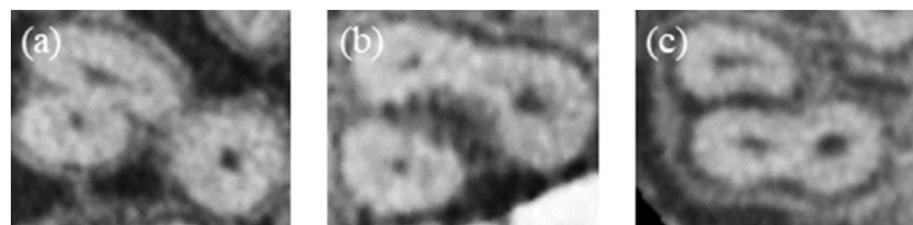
Representative CBCT scans of maxillary first molars exhibiting root fusion classified with the Zhang classification.²³ (a) Type 1; the MB root is fused with DB root. (b) Type 2; the MB root is fused with P root. (c) Type 3; DB root fused with P root. Type 4 (MB root fused with DB root, and P root fused with MB root or DB root), type 5 (P root fused with MB root and DB root), and type 6 (P root, MB and DB root fused to form a cone-shaped root) were not identified.
